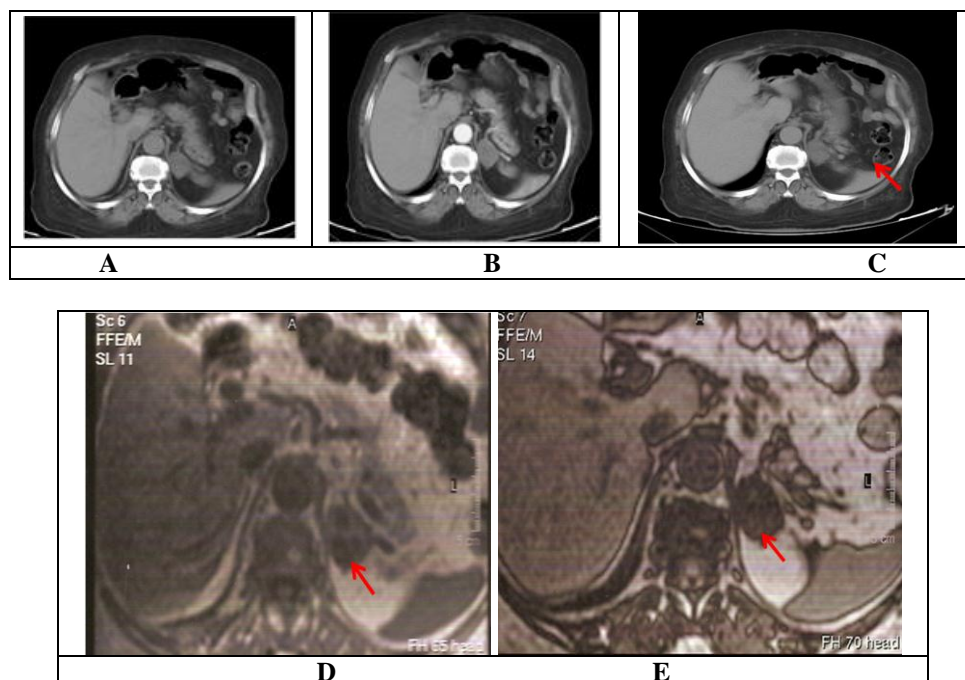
Male patient, 69 years old, complaint: Recurrent attacks of nonspecific abdominal pain. Normal Laboratory tests, 10 minute delay washout CT (A) precontrast, (B) early contrast enhancement and (C) delayed images, axial scan, well defined left adrenal mass with rapid contrast wash out APW 83.7% and RPW 51.6%, chemical shift MRI (D) in phase (E) out in Phase: the lesion showed drop of signal intensity on out of phase relative to in phase. Finding consistent with left adrenal adenoma.
